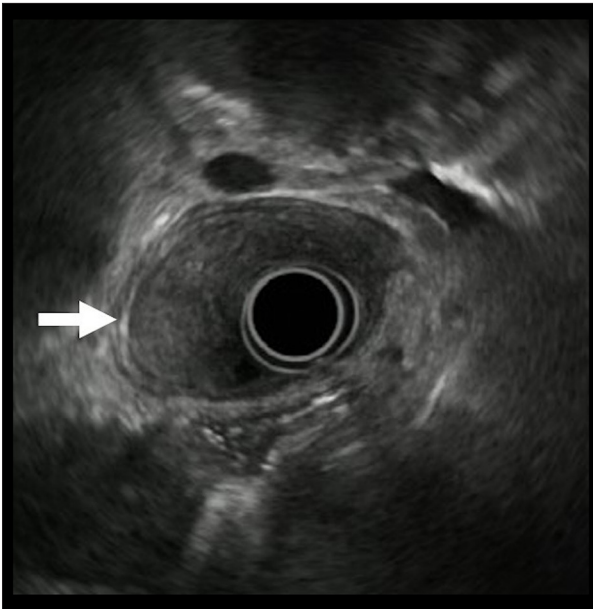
Endoscopic ultrasonography image of the esophagus. The arrow shows a homogenous hypoechoic lesion in the submucosal layer that was diagnosed as an intramural hematoma.
